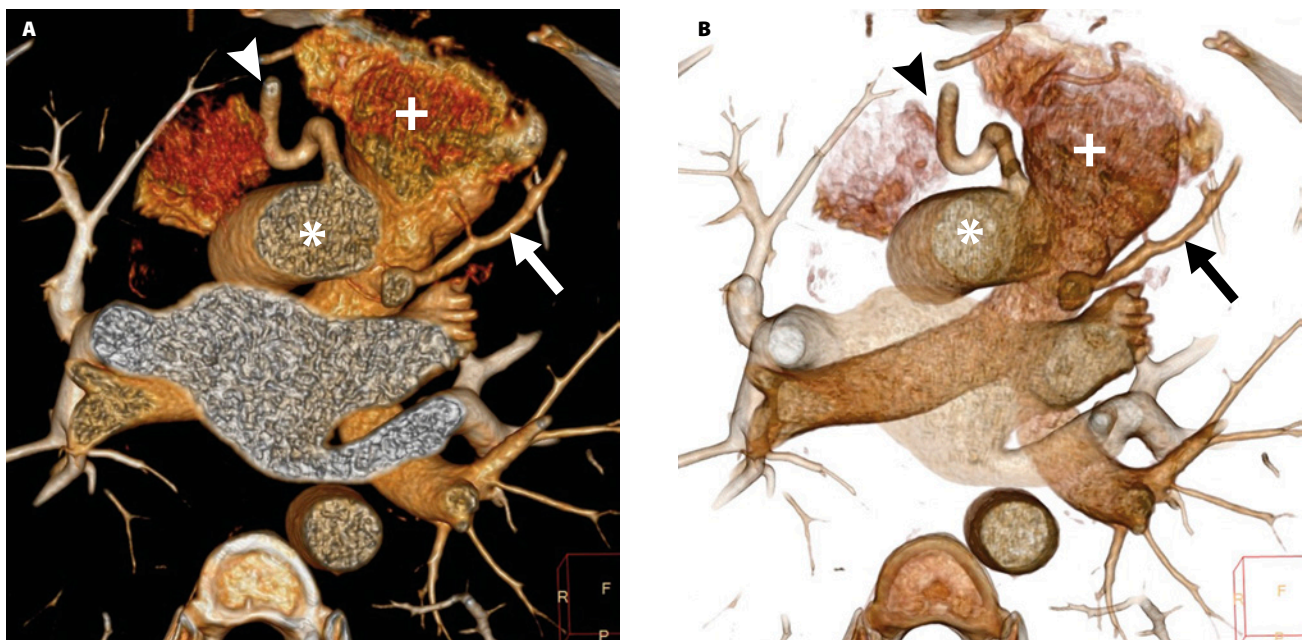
A. Three-dimensional computed tomography (CT) volume rendering shows the right main coronary artery (arrowhead) arising from the ascending aorta (*). B. The arrow indicates the anomalous left main coronary artery arising from the inferior pulmonary artery (+). Images courtesy of the authors.
